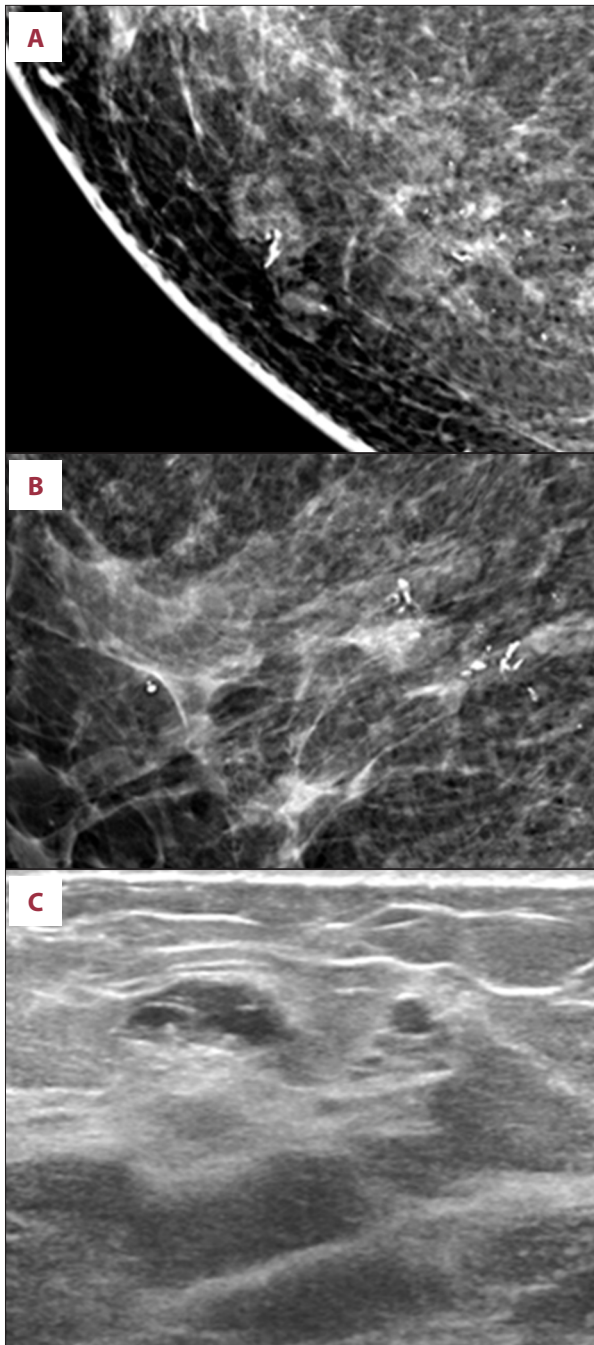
The craniocaudal (A), mediolateral (B) magnification mammograms of the right breast show multiple aggregated irregular or oval masses, and focal asymmetries accompanying regional coarse heterogeneous calcifications, which extend approximately 8 cm in the inner central area (arrows). Transverse (C, D) and radial (E) grayscale sonograms scanned in the corresponding area of the right breast show multiple aggregated cystic lesions. The cysts have multiple septa, and complex cystic and solid internal echoes (C-E). On a radial scan, the cysts tend to be connected like a ductal structure (E).
